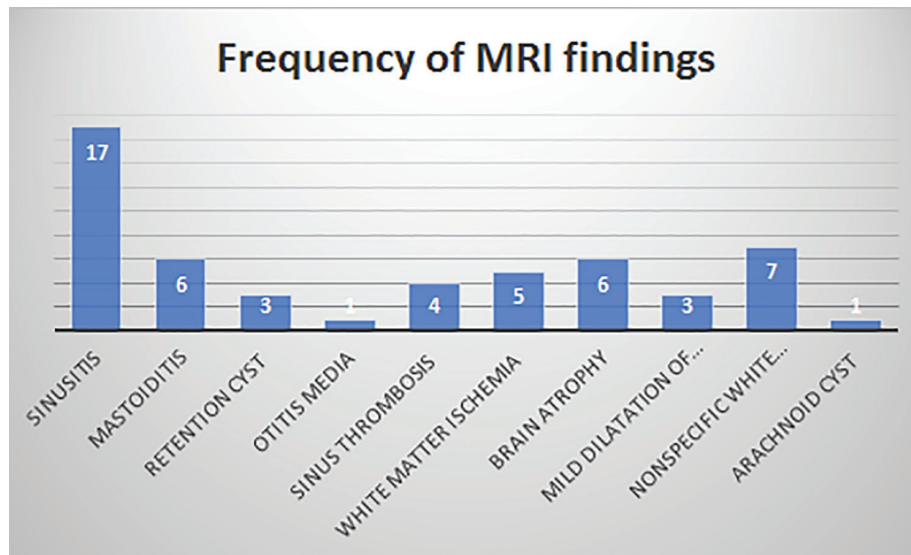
Frequency of MRI findings in the study population
